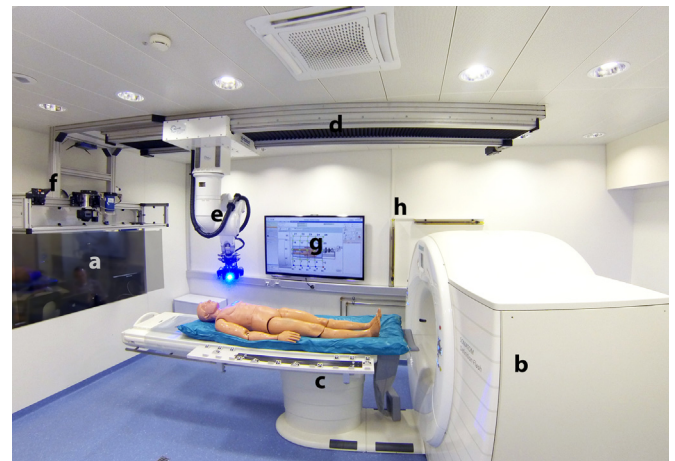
CT room with Virtobot installation. a: Workstation area. b: Dual-source CT scanner. c: CT table with marker board attached to side rails. d: External rail of the Virtobot. e: 6-axis robot arm with mounted surface scanner. f: Tool stand with digital photo camera and biopsy module. g: Presentation and Observation screen. h: Safety light fence for device protection.
